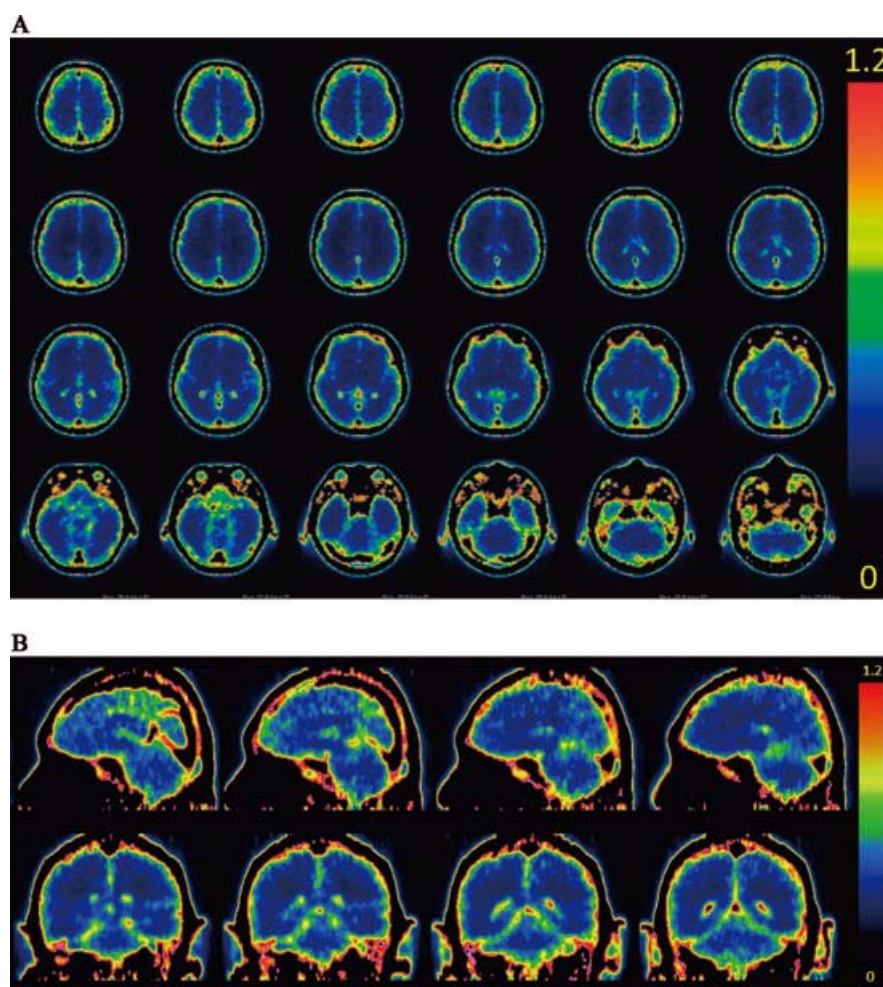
Images constructed with filling pixels, which showed the SUV over 1.2, in black. Axial images based on identical data [Fig 1 (A)] and representative images of sagittal and coronal views (B). All images were constructed based on the frames acquired 15–60 minutes post injection. Distribution of radioactivities within the brain are highly consistent with known distribution of AQP-4, namely, subpial, and perivascular endfeet of astrocytes. Choroid plexus, where both AQP-4 and AQP-1 are known to be significantly expressed, also showed significant uptake.
